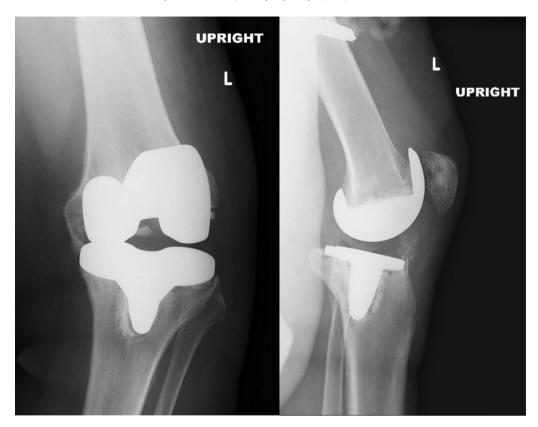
Pre-operative radiographs at initial presentation demonstrating prior left TKA.
